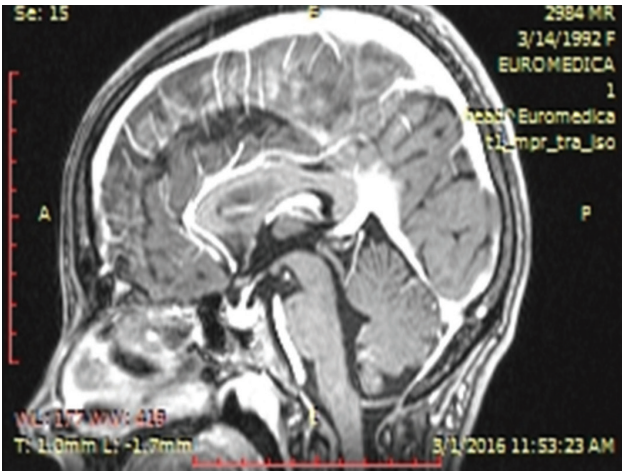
MRI: Idiopathic Intracranial Hypertension.
